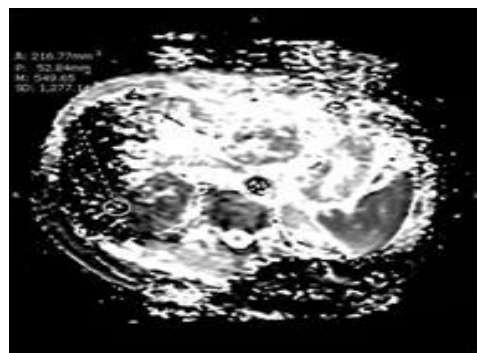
51 years old male patient with liver cirrhosis and HCV + VE underwent TACE of right hepatic lobe lesion segments VI focal lesion. Dynamic MRI with diffusion weighted study and ADC mapping was done 3 months after embolization. (A) Axial arterial phase image showing early peripheral enhancement and (B) Axial delayed phase image showing delayed washout, (C) the lesion showing partially restricted diffusion on (DWI). (D) ADC mapping and ADC value 1.0×10^{-3} denoting residual activity.
